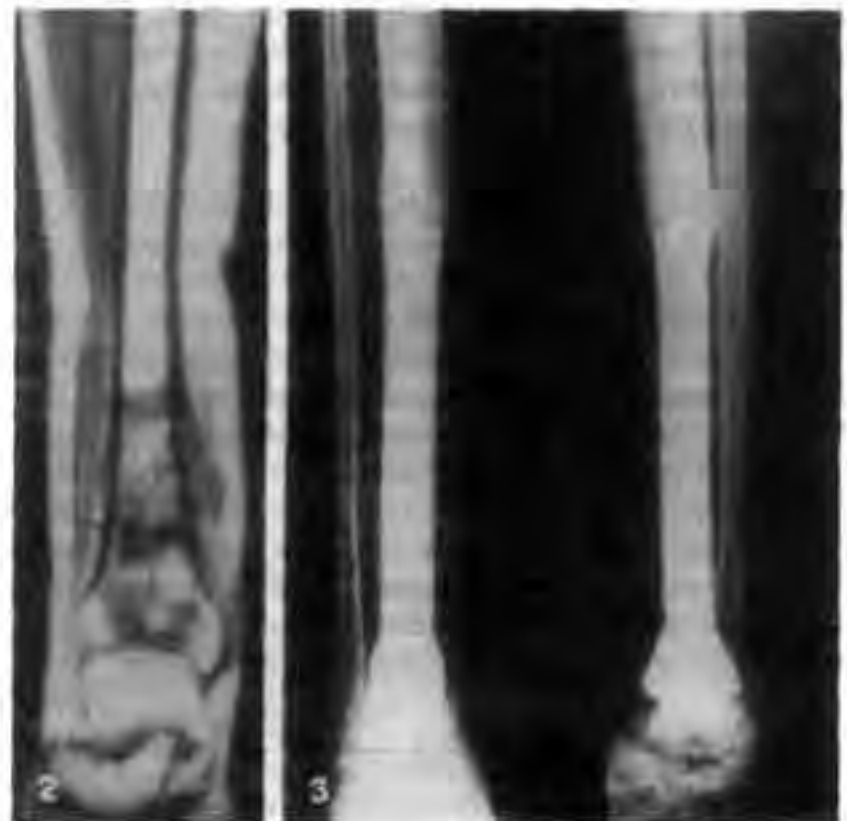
Radiograph showing distal tibial osteosarcoma in a 20-year-old man
